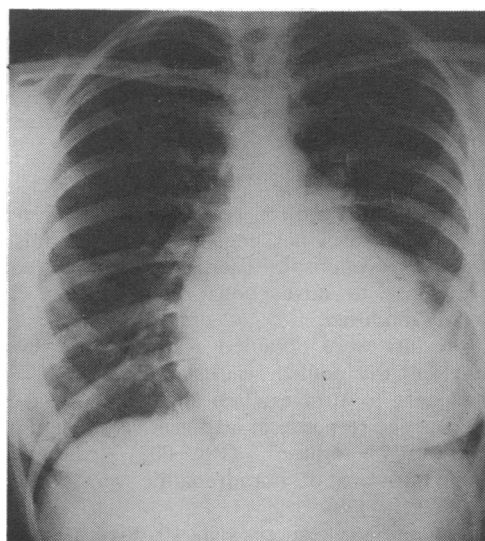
Preoperative chest x-ray film, showing enlargement of both left atrium and left ventricle with pulmonary congestion.
